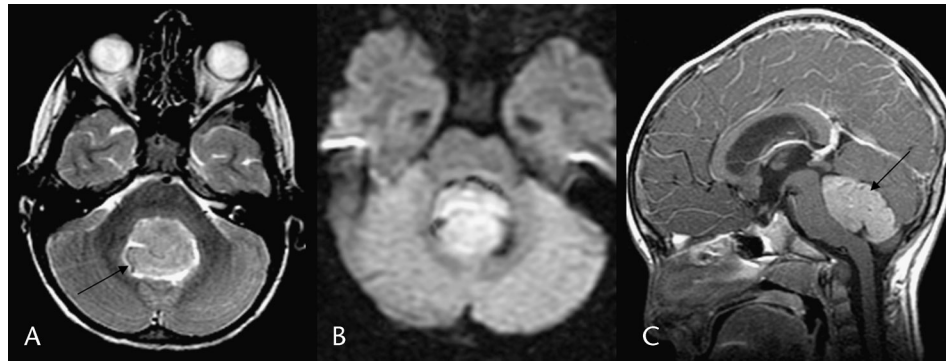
“Typical” medulloblastoma in a 5-year-old child. Axial T2 (A), DWI (B), and sagittal postgadolinium T1 (C) images show a midline posterior fossa mass (black arrows) growing into the fourth ventricle and associated with HC. The mass is T2 isohypointense to gray matter and CSF, DWI hyperintense (reduced diffusion), and markedly enhances.
